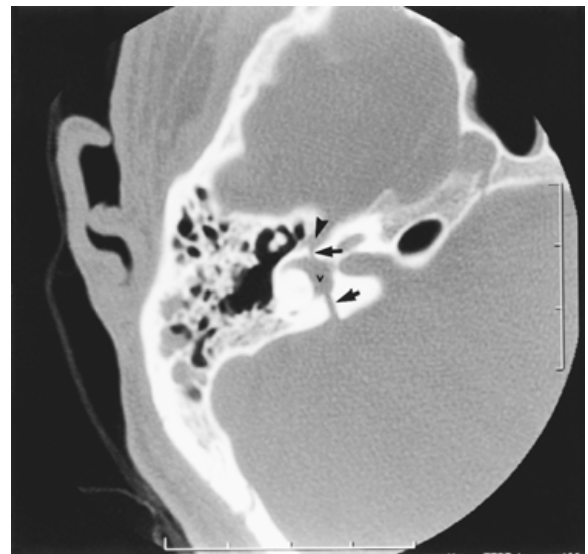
Transverse temporal bone fracture, axial computed tomography. A fracture line traverses the temporal bone, running perpendicular to the long axis of the bone (black arrows). The fracture traverses the vestibule (v) and extends into the geniculate ganglion (arrowhead).
